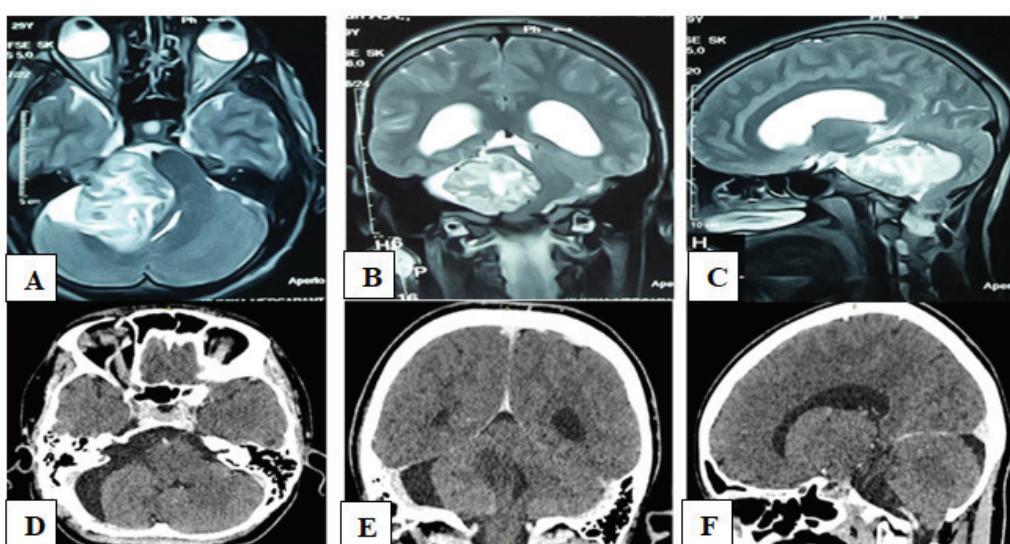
Vestibular schwannoma, 47x62x41mm (MRI preop - Fig. 2A, B, C).
